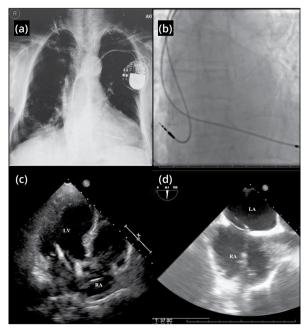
(a) Chest radiography. (b) Fluoroscopic image. (c) Transthoracic echocardiographic image (apical four chamber). (d) Transesophageal echocardiography image (bicaval view).
